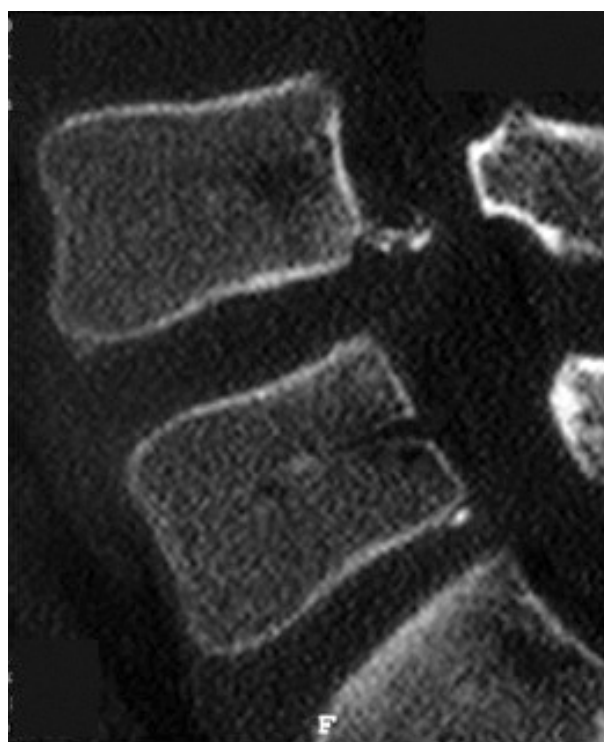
Sagittal reconstructed computed tomography scan showing the fractured apophyseal ring of the lower endplate of L4
